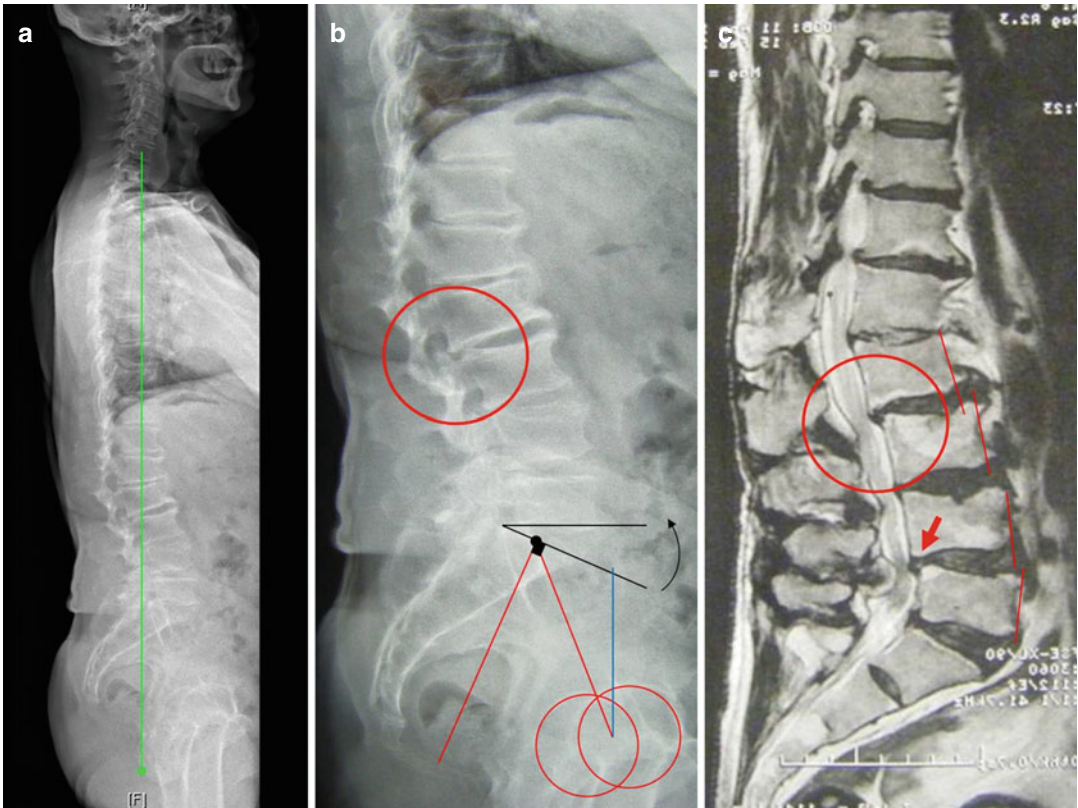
Patient with lumbar stenosis from L2–L3 to L4–L5 and thoracolumbar kyphosis: full spine radiographs (a), X-rays focused on lumbo-pelvic zone (b) and sagittal T2-weighted MRI sequence (c). The patient is well balanced (C7PL/SFD is -0.3); however, some compensatory mechanisms are present in the lumbar area.
